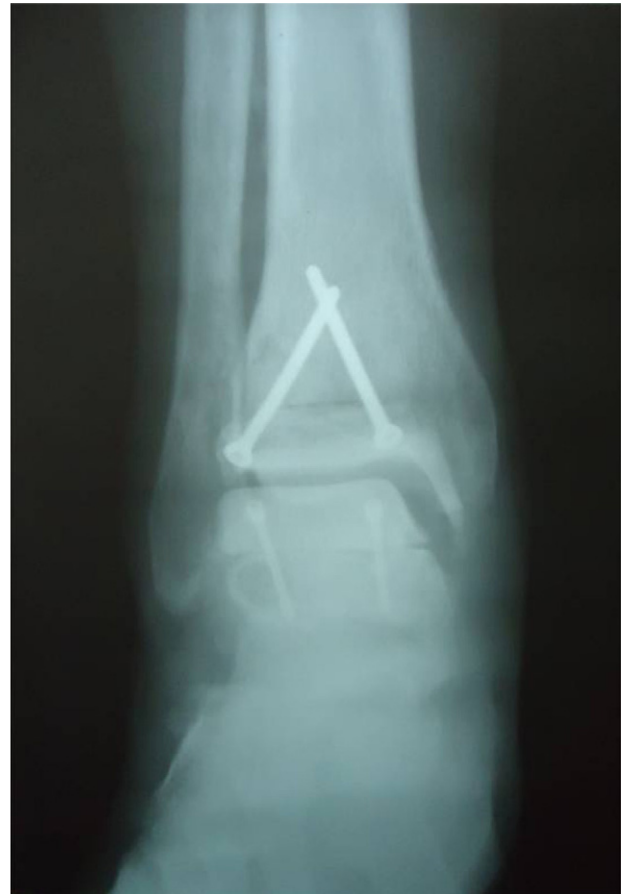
X-ray of the right ankle three months after surgery.
